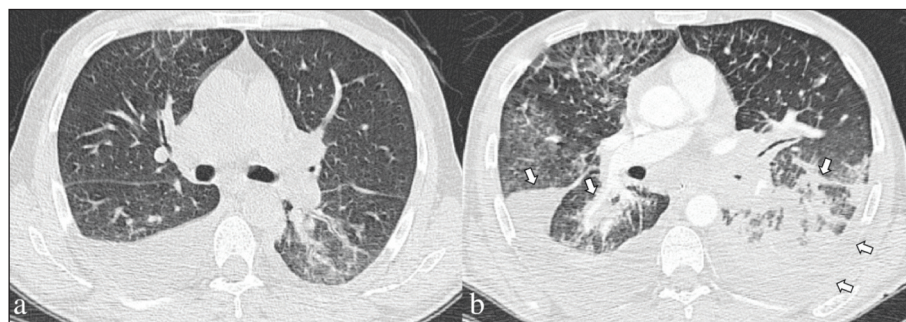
Thoracic computed tomography images before (a) and after (b) treatment with pembrolizumab.
